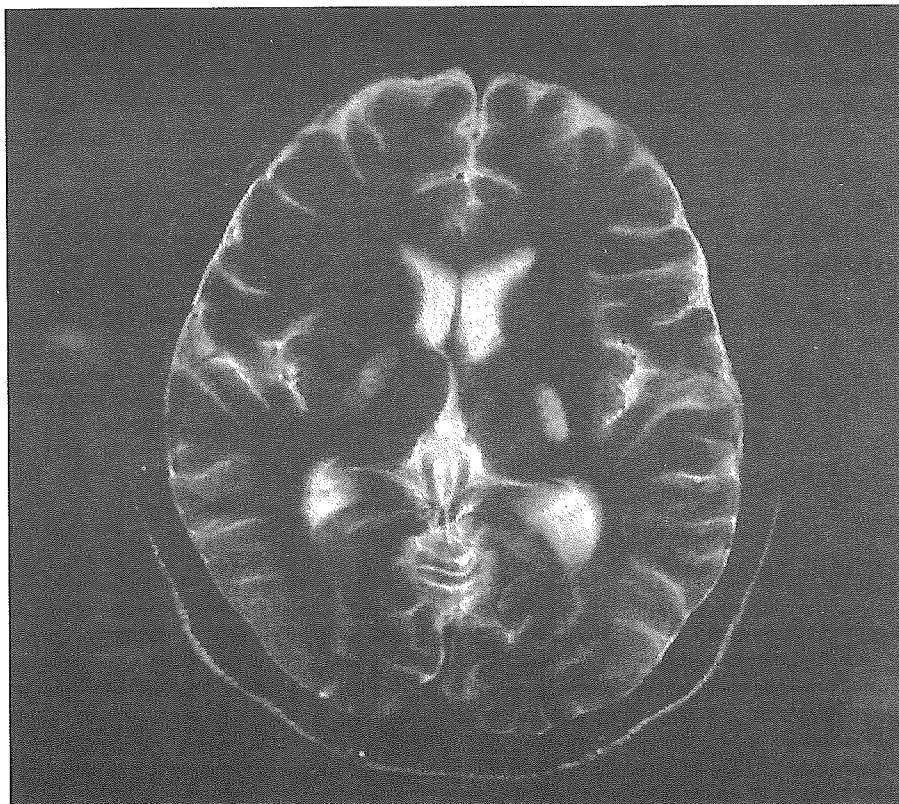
T2-weighted MRI of the brain of a 41-year-old man with AIDS demonstrating bilateral hyperintense lesions in the basal ganglia (arrows)
